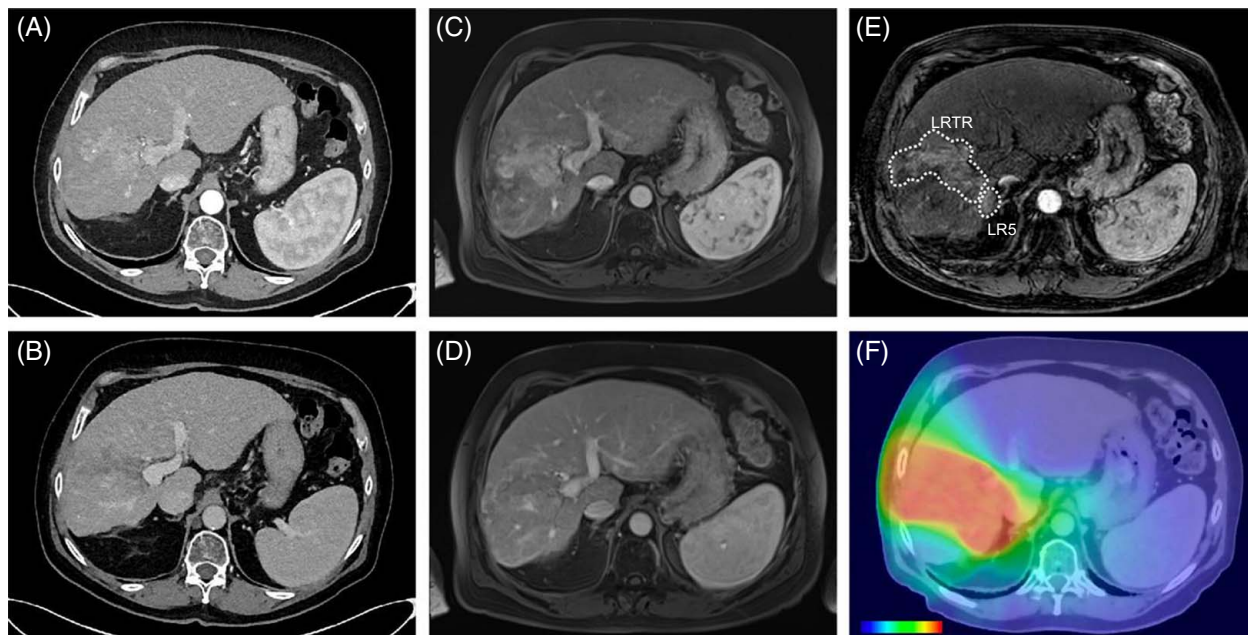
65-year-old-man with recurrent HCC and de novo HCC. (A) Arterial phase CT showing large (7.6×4.6 cm) LIRADS-TR (LR-TR) representing residual tumor lesion previously treated with TACE. (B) LR-TR equivocal lesion demonstrating wash out in venous phase (80 s). (C) T1 MR of gadobutrol (Gadavist) arterial (20 s) and (D) venous phase (70 s). (e) T1 MR of gadoxetate disodium (Eovist) arterial phase (20 s) showing LR-TR equivocal lesion and an additional LIRADS-5 lesion. (F) Dose color wash of stereotactic ablative radiotherapy encompassing both lesions to the prescribed dose of 45 Gy in 5 fractions (scale represents 0–49 Gy). Abbreviation: TACE, transarterial chemoembolization.
